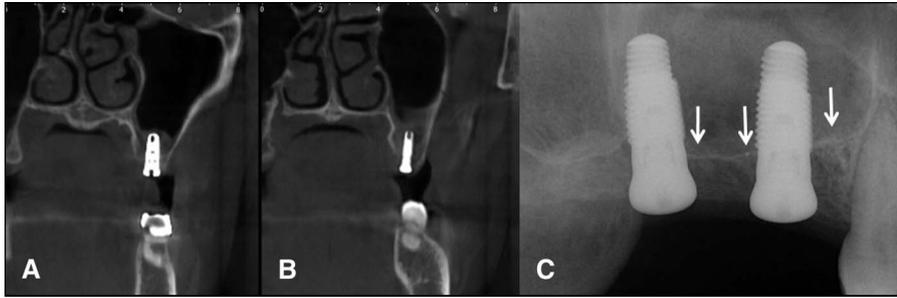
Immediate postoperative CBCT and periapical radiogram demonstrating the elevated sinus membrane. All axial aspect of CBCT showing the sinus membrane elevation in the lateral approach. A, Approximately 10 mm of membrane elevation on the right first molar area. B, Approximately 13 mm of membrane elevation on the right second molar area. C, The original sinus floor was observed on periapical radiogram (arrow).
